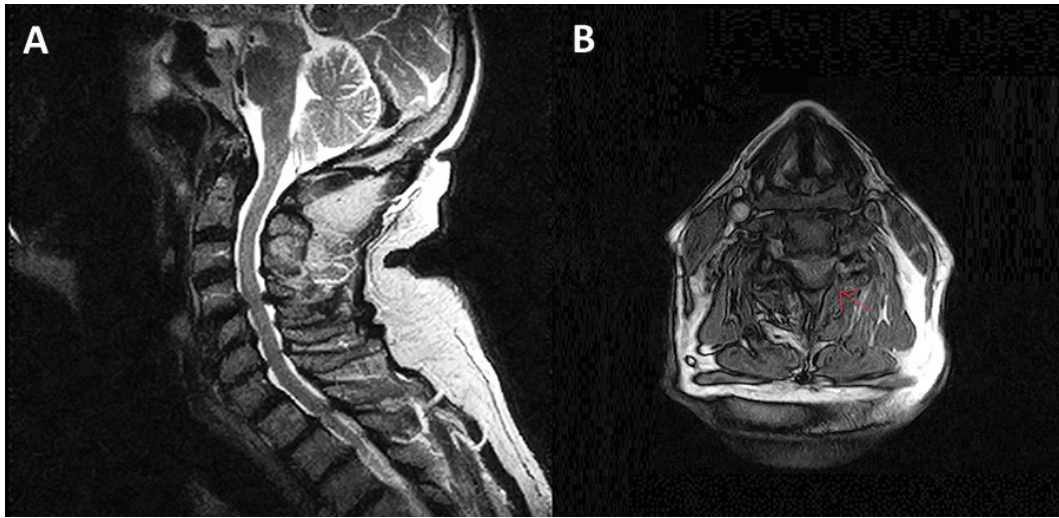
A. T2 sagittal MRI and B. T2 axial MRI (right) of the cervical spine demonstrates moderate to severe spinal cord compression at C4-5 and C5-6. The red arrow points at the compressed spinal cord. There is no evidence of spinal cord edema.
